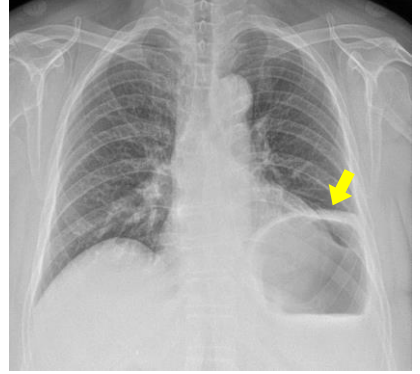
Left diaphragm elevation (arrow) shown in chest X-ray
